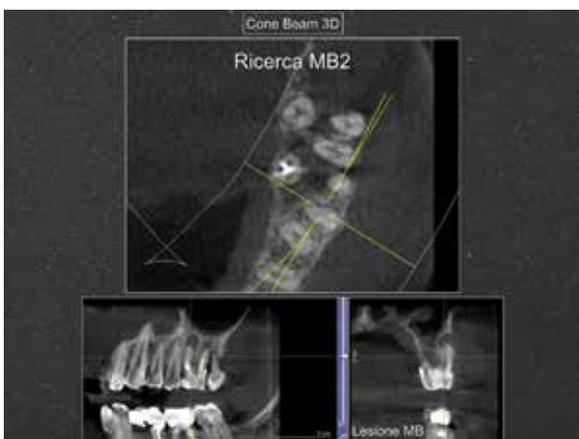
At transverse section (CBCT) of the mesio-vestibular root the presence of the fourth canal was not detected.
